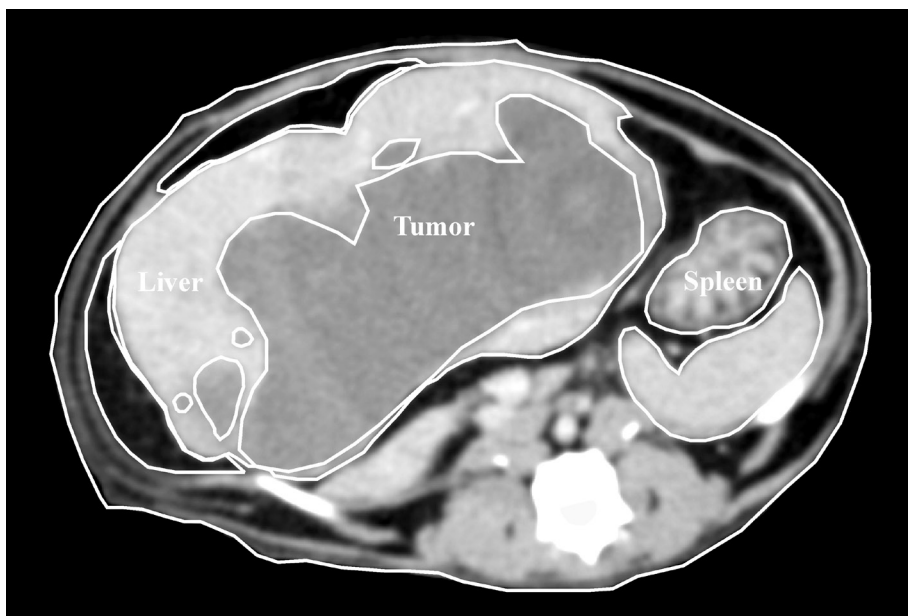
Segmented CT image for dose planning of the MELT patient
